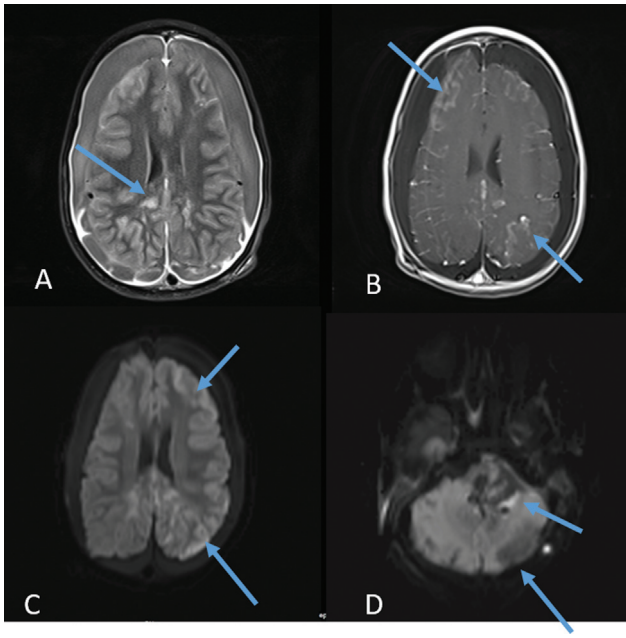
Postoperative late magnetic resonance imaging (MRI), developing necrotic changes. (A) Fluid-attenuated inversion recovery sequence MRI showing cytotoxic edema (blue arrow). No periventricular lucency and bilateral subdural hygroma formed, these signs showing intracranial pressure drop. (B) T1 sequence MRI with contrast enhancement showing cytotoxic edema in frontal and parietal regions (blue arrows). (C) Diffusion MRI showing cytotoxic changes in frontal and parietal regions (blue arrows). (D) Diffusion MRI showing cytotoxic changes in cerebellum (blue arrows).
